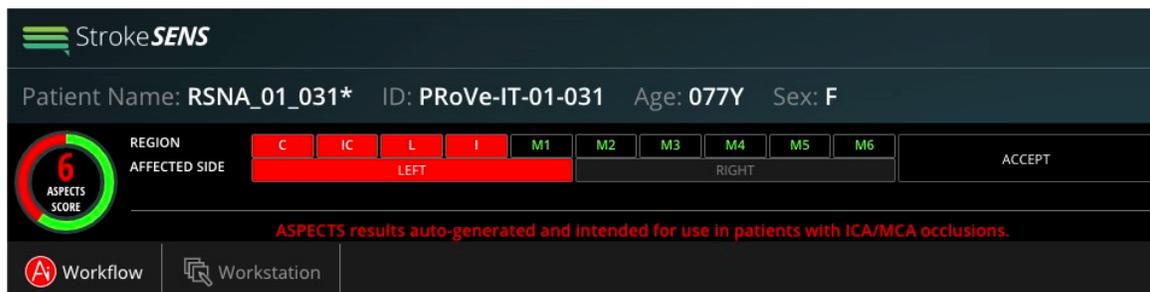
Auto-generated ASPECT score for clinician review and acceptance
